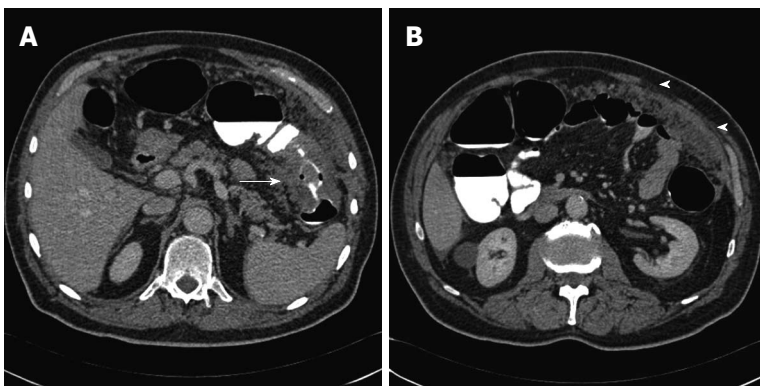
Computed tomography colonography of a T3 M1 stenosing lesion in the transverse colon. A: A Computed tomography colonography (CTC) axial source image shows the lesion (arrow); B: A CTC axial source image depicts marked omental thickening (arrowheads) consistent with peritoneal carcinosis.
